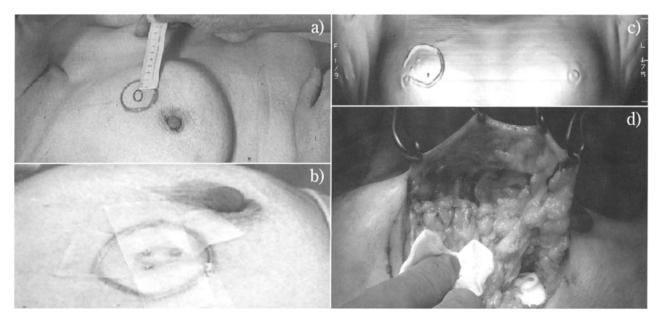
Three-dimensional contrast-enhanced helical CT imaging-guided breast lumpectomy. a) Extent of resection is proposed at 1.0 cm from the tumor by palpation and/or ultrasonography. b) Radiopaque wire is placed on the skin where breast lumpectomy is required. c) 3D display: Preoperative margin was evaluated by the 3D display. The relationship between the breast cancer and the nipple can be visualized three-dimensionally. d) Partial resection of the breast is performed in guidance using sticky blue dye intraoperatively.
